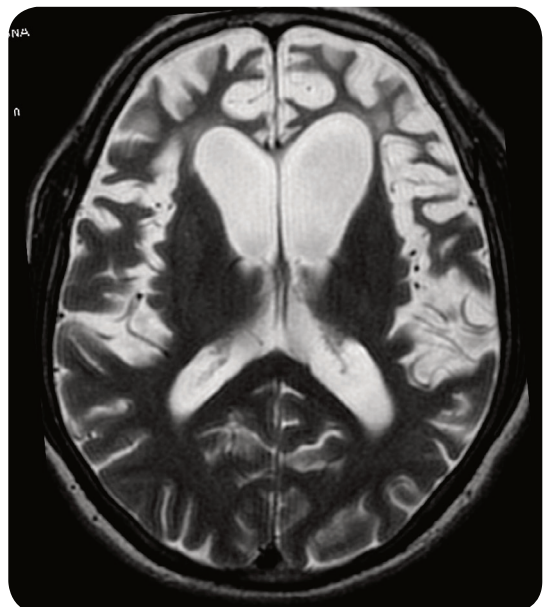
An MRI scan of the head in the axial plane demonstrating frontotemporal volume loss.
